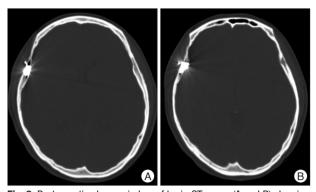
Postoperative bone window of brain CT scans (A and B) showing complete obliteration of dural arteriovenous fistula (DAVF) via transarterial Onyx embolization. The Onyx cast is demonstrated within the diploic space on right parietal bone, which confirms intraosseous DAVF.
